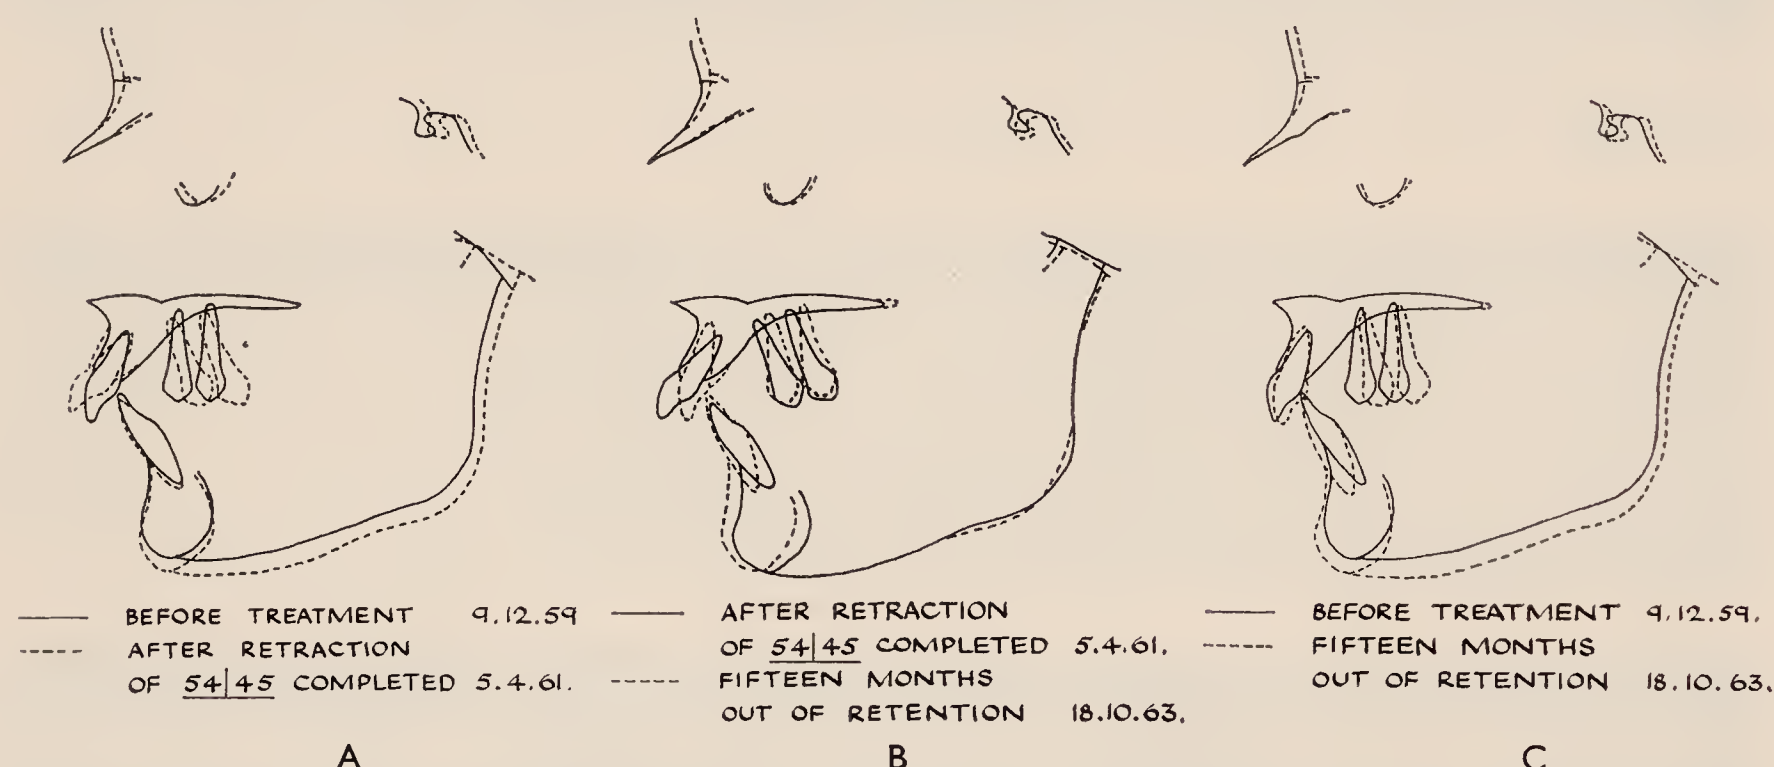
Tracings of lateral skull radiographs of Patient K.B., superimposed on ANS and the maxillary plane, showing changes in upper premolars. A, During treatment. B, Following treatment. C, Overall.
